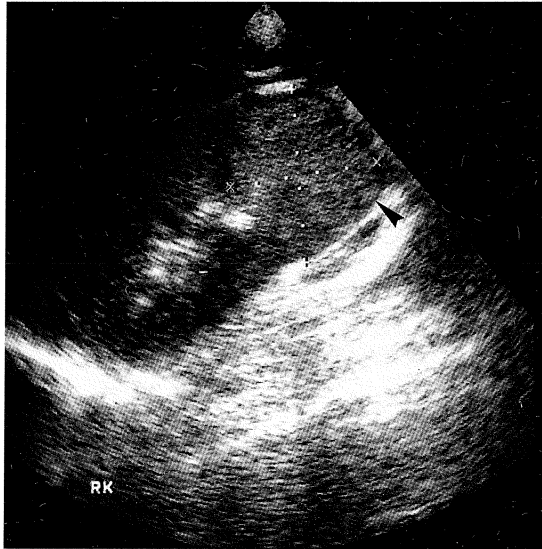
Ultrasound scan of the right kidney.
